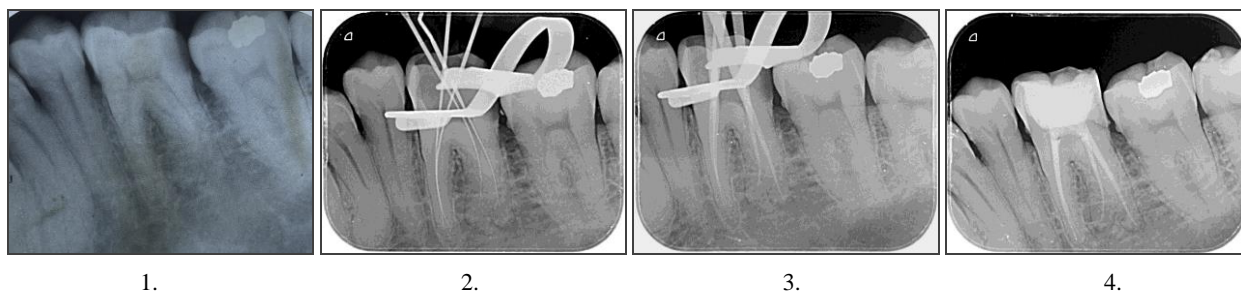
1. Preoperative radiograph 2. Working length of 36 3. Master cone 4. Completion of root canal treatment and permanent access restoration
